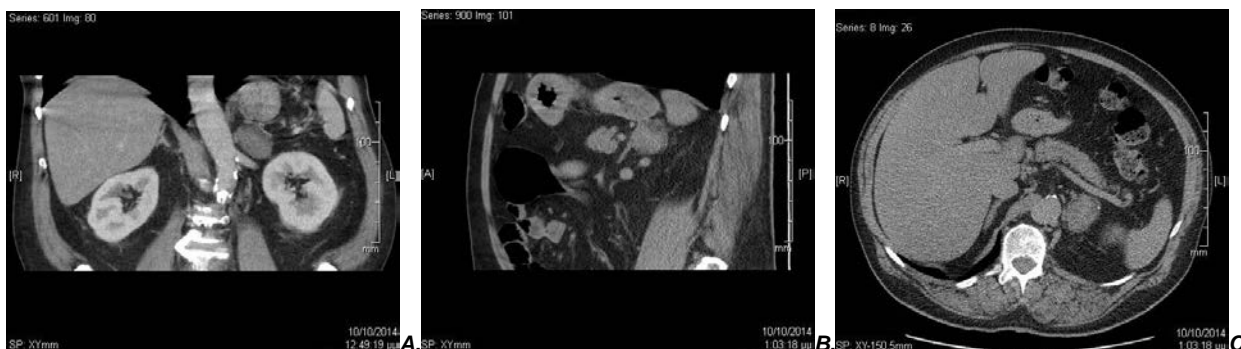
A,B,C: CT scan shows a mass with mild inhomogeneous solid characteristics and an oval size about 42x38x32mm
